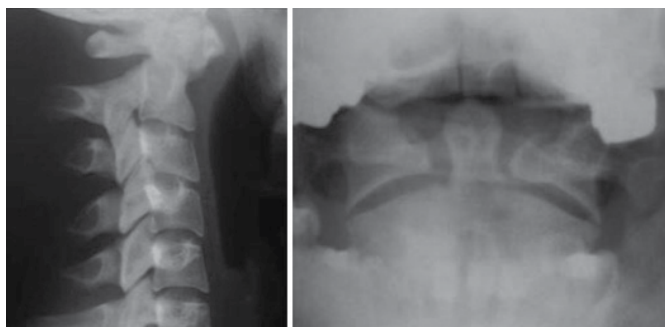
Lateral and trans-oral x-ray of the neck in a patient with Type II odontoid fracture.
